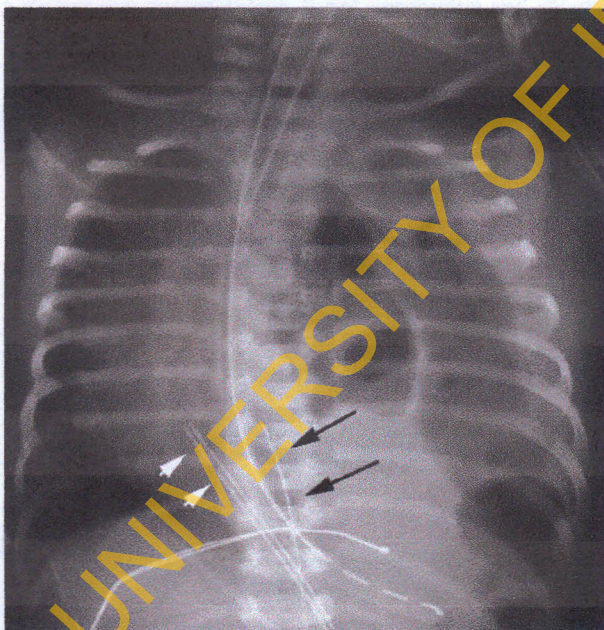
A 1-day-old infant with left Bochdalek hernia. Chest radiograph shows moderate deviation of the umbilical venous catheter (short arrows) and minimal deviation of the umbilical artery catheter (long arrows) to the right
